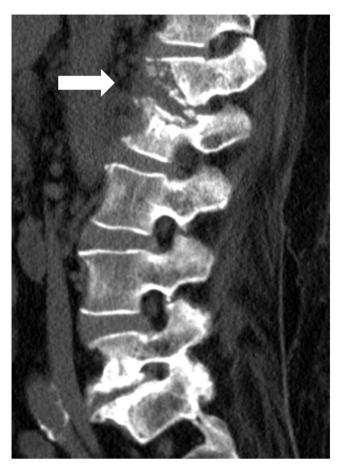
CT of the lumbar spine showing stable compression deformity at the L1-L2 level and new L1-L2 discitis.
